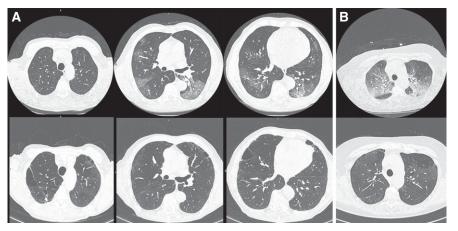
Representative high-resolution chest computed tomographic (HRCT) images of two of the survivors. (A) HRCT imaging performed at admission (upper row) and at 3-month follow-up (lower row). Chest computed tomographic (CT) imaging at admission shows typical bilateral subpleural ground-glass opacities. No signs of previous emphysema were detected. However, follow-up HRCT imaging shows obvious emphysematous destruction. (B) CT image at presentation at emergency department with evident ground areas with reticulation (crazy paving). Follow-up reveals diffuse areas of persistent ground glass without reticulation, as well as areas with low density in previously normal areas, possibly due to hypoperfusion.
